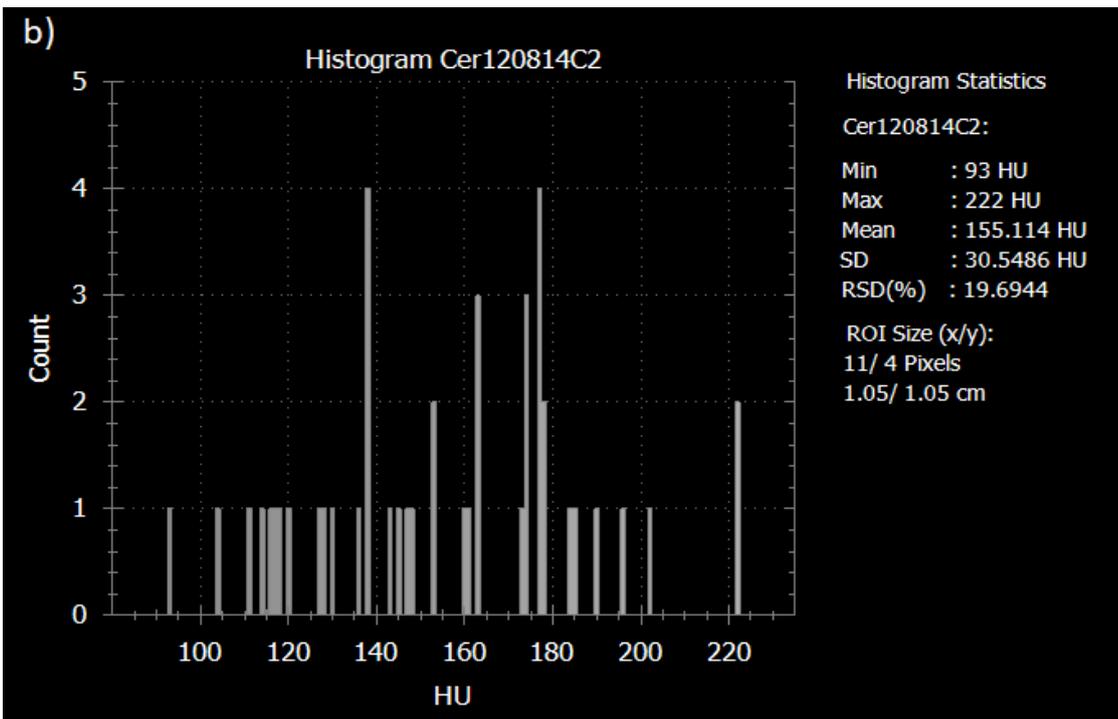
Region of interest (ROI) placement for the measurement of CT density (in HU) in the planning CT (a). In the sagittal plane of the planning CT, a square ROI (red) half the height of the lumbar vertebra was placed in the ventral half of the trabecular compartment of the 1st
